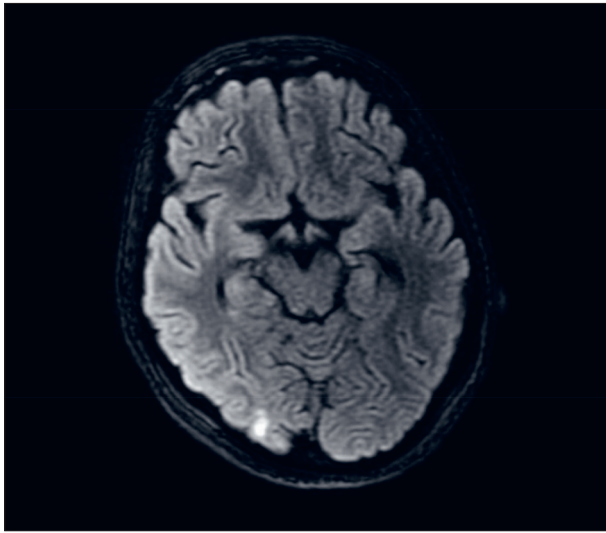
Control brain MRI showed minimal hyperintensities in the right occipital region
